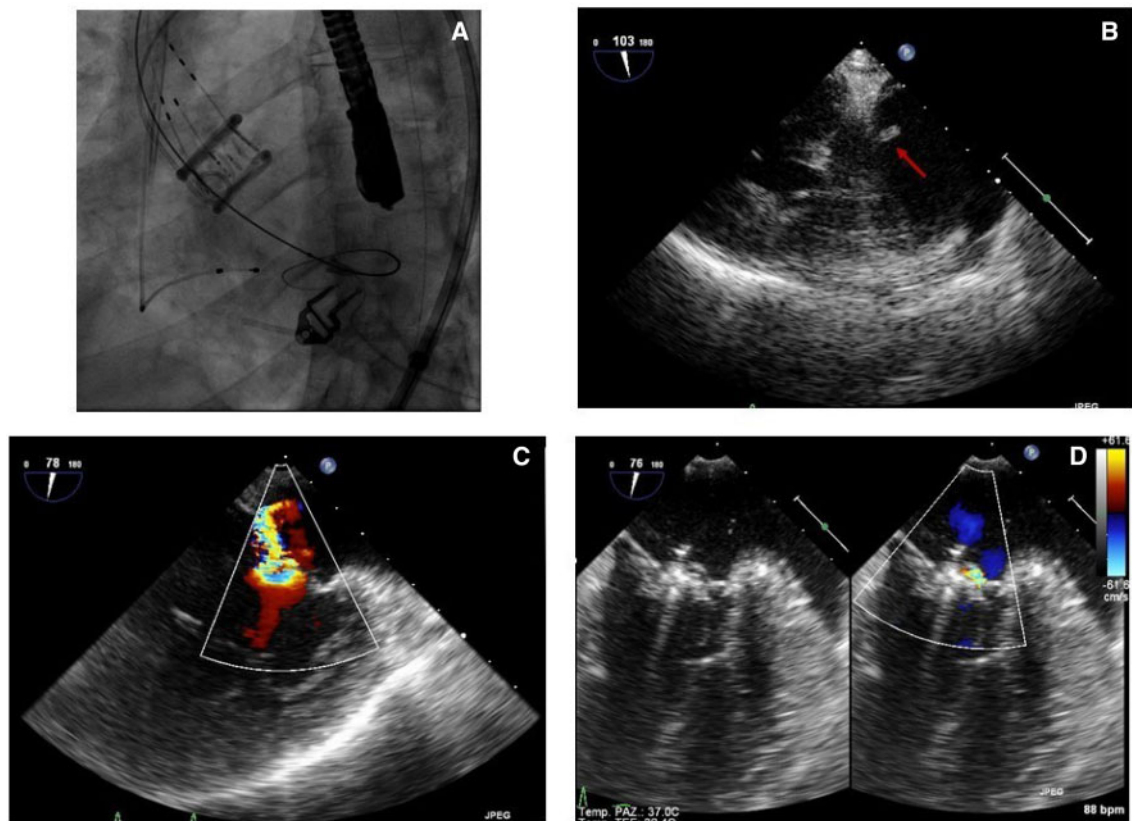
(A) Fluoroscopic imaging of Direct Flow valve implantation. (B) TEE transgastric view showing papillary muscle rupture. (C) Colour Doppler mid-oesophageal view showing severe mitral regurgitation. (D) Mild residual mitral regurgitation after urgent Mitraclip implantation.
